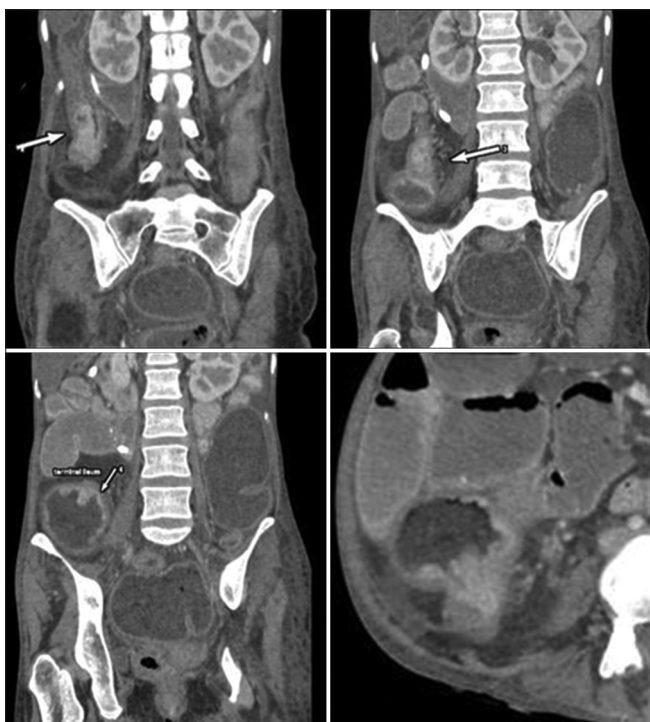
Multidetector computed tomography enteroclysis-enteroclysis in a 36-year-old female patient who presented with chronic diarrhea on and off for the past months showed bowel wall thickening with mucosal enhancement in the terminal ileum. An irregular polypoidal lesion showing contrast enhancement was noted in the ileocecal region and cecum, causing low-grade small bowel obstruction with prominent mesenteric vasculature
